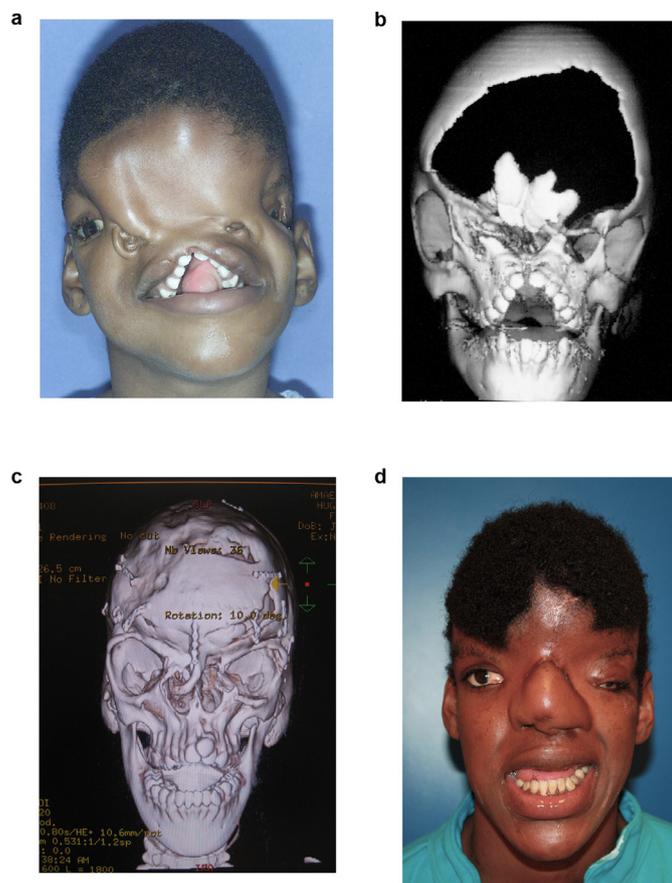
(Permission to reproduce figures 3a and 3b from reference 21. a: A 6-year-old girl from Nigeria with an extremely large median craniofacial cleft (Tessier 0-14) presenting several frontal encephaloceles and the absence of frontal bone, as well as a large widow's peak covering virtually the whole forehead. She had a severe hypertelorism of approximately 120 mm interorbital distance; a large left upper eyelid coloboma, which had led to corneal opacity; and a large centrofacial cleft with the absence of the nose (two nostril remnants being present) and a median cleft lip. Her palate was ogival and intact. She presented with left amblyopia. b: CT scan of the same patient showing the large craniofacial cleft of the midline, absence of the frontal bone, and midfacial cranial tilting, as well as extreme hypertelorism with lateral orientation of the orbits. Her palate was extremely arcuate. c: CT scan at 5-year follow-up showing good general bony consolidation, although some small bony defects persisted. The contour of the facial skeleton is greatly normalized with a persistent stable moderate hypertelorism of approximately 4 cm. d: At 11-year follow-up. Further, she had another nasal correction for deviation of the rib graft and left medial canthopexy 5 years after the initial surgeries. Note the good stability of the facial height, although bony correction was necessary during the period of facial growth.
